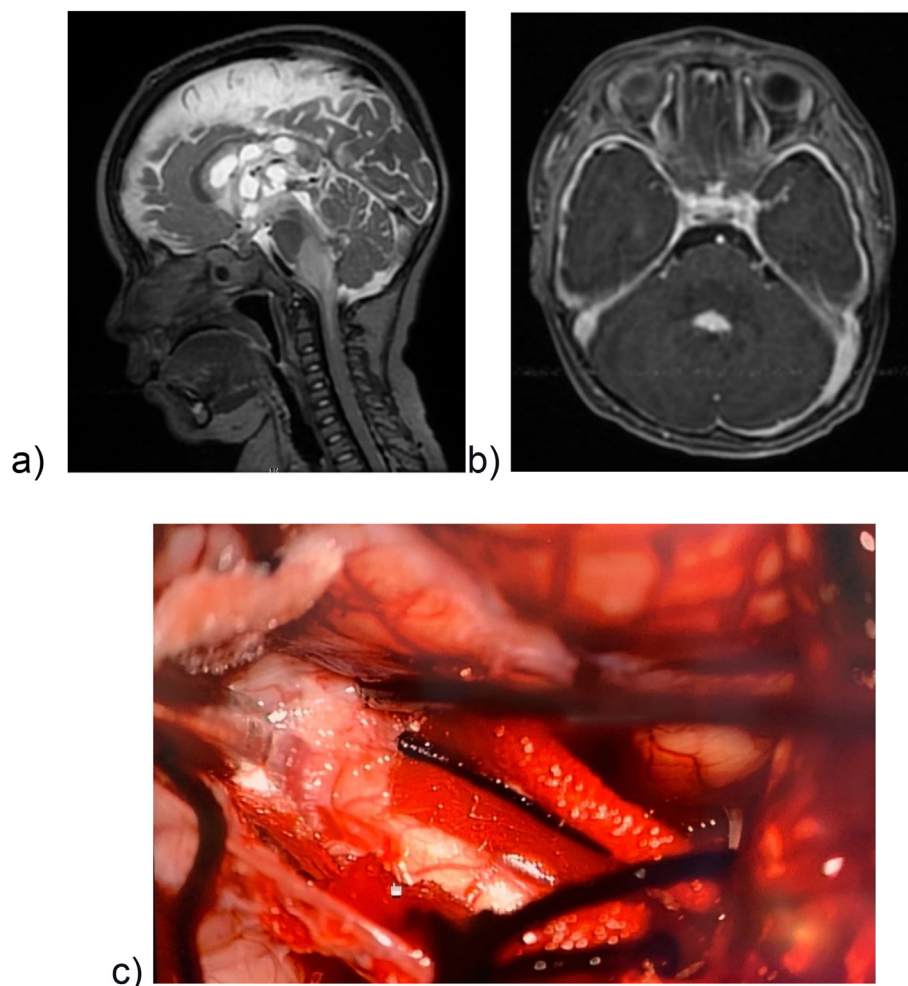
Brain abscesses and fourth ventricle tuberculoma. a) Sagittal T2 MRI showing multiple brain abscesses b) Transverse MRI enhanced with Gd showing a tuberculoma located in the fourth ventricle. c) Intraoperative visualization of the tuberculoma.
